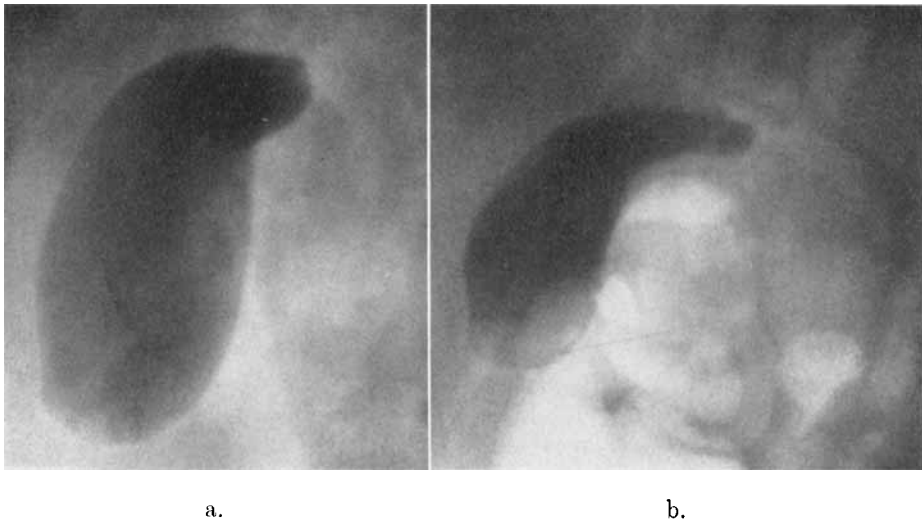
Normal cholegraphy with Biligradin. a. Radiograph 2 hours after injection of 20 ml Biligradin. b. Radiograph 30 min. after egg-yolk meal. Visualization of large extrahepatic biliary passages.
